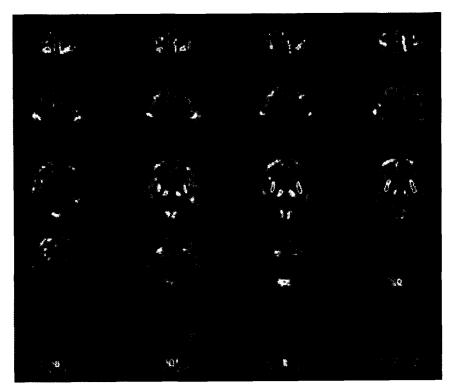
Sixty-seven years old male with dementia with Lewy body. Axial image of F-18 FDG PET show significant cortical hypometabolism involving bilateral parietotemporal cortex and occipital cortex.
